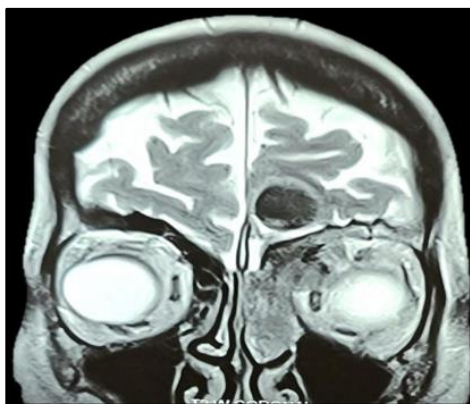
Pre-operative MRI of oncocytic schneiderian papilloma
